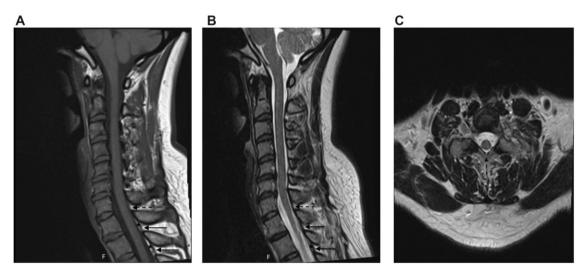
A. Cervical spine T1-weighted MRI, midline sagittal plane. Note the solid arrows at the T1–T2 and T2–T3 levels pointing to ligamentum flavum. Immediately ventral to ligamentum flavum is "adequate" epidural fat, which appears as a white structure that lies between the dura and ligamentum flavum and is demarcated by an asterisk (*). Also, note the dotted arrow at the C7–T1 level that reveals no appreciable epidural fat or ligamentum flavum, which is significantly different in appearance compared to the T1–T2 and T2–T3 levels. B. Cervical spine T2-weighted MRI, midline sagittal plane. Note the dotted arrow at the C7–T1 level that reveals neither appreciable ligamentum flavum nor epidural fat, which if present, would appear as a sliver of white just dorsal to the thecal sac. At the T1–T2 and T2–T3 levels, ligamentum flavum is noted (solid arrows). Significant epidural fat is notable at the T2–T3 level (*), while only a miniscule amount is notable at T1–T2. C. Cervical spine T2-weighted MRI, axial plane at the level of the C7–T1 disc. Note the dotted arrow that points to a gap in ligamentum flavum, indicating that the ligamentum flavum is not fused in the midline. Additionally, there is no appreciable epidural fat, which if present, would appear as a sliver of white just dorsal to the thecal sac.
